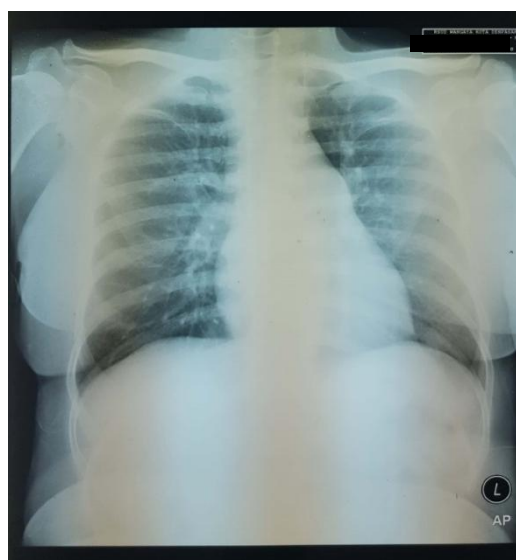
Patient's chest X-Ray
